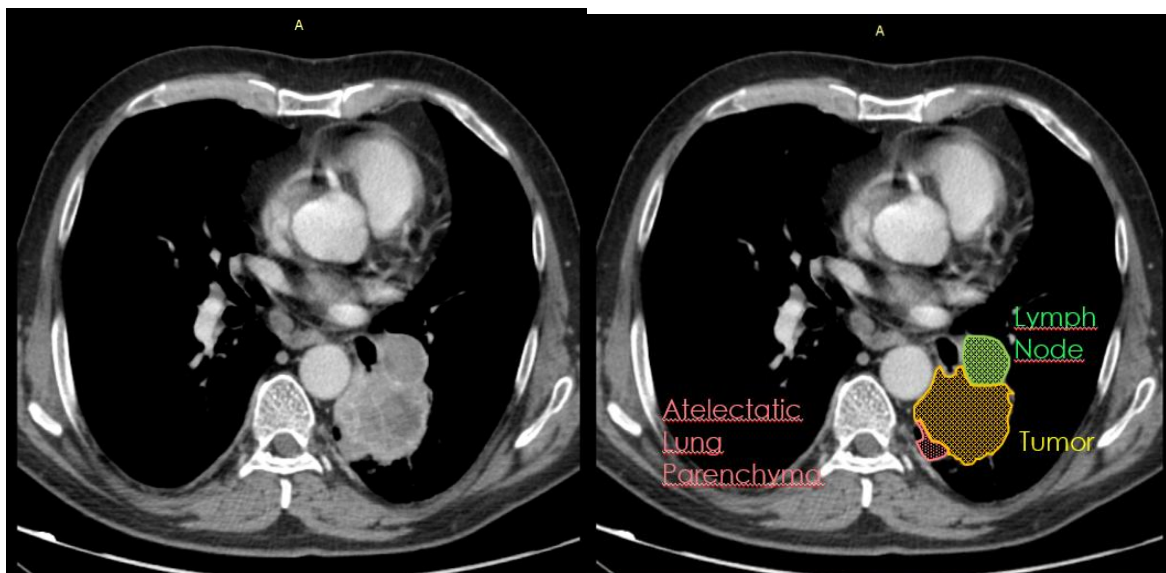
Baseline CT of a left lower parahilar lung mass showing a heterogeneous mass with three distinct components that highlight the difficulty of segmentation: primary lung tumor (yellow), pathological hilar lymphadenopathy (green), and atelectatic lung parenchyma (red).
